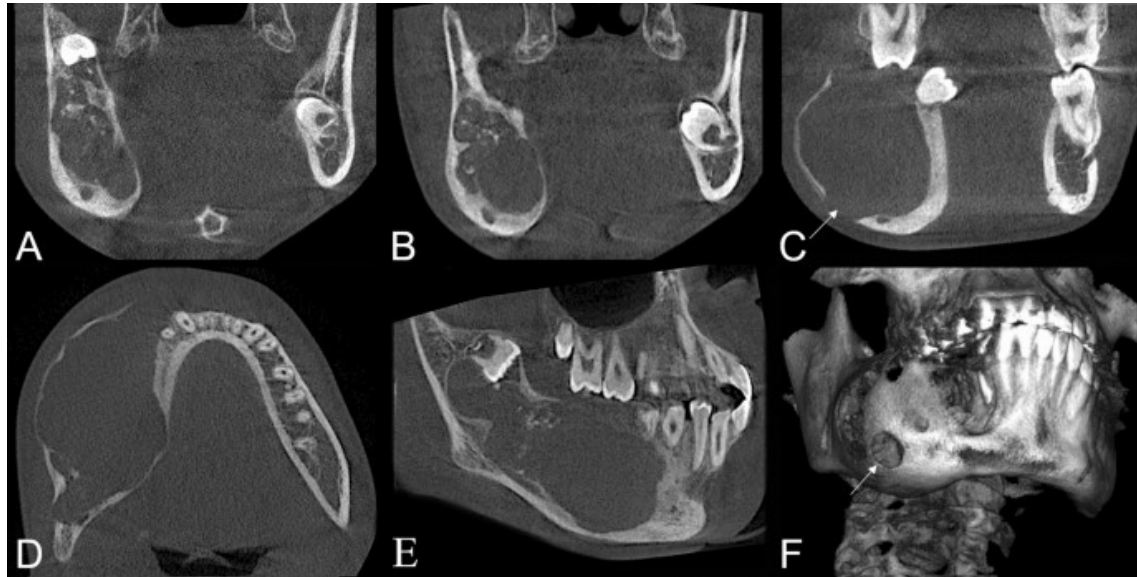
Coronal (A, B and C), axial (D), sagittal (E) and three-dimensional reconstructed (F) CBCT images after 3 years showing a soft tissue lesion with internal calcifications. The tumour showed increased expansion with cortical disruption (arrow)
